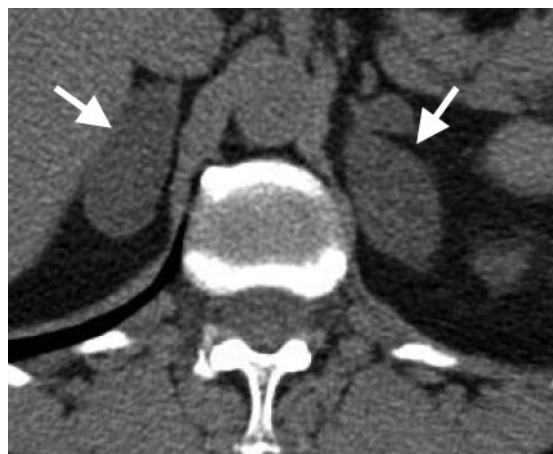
Bilateral adrenal masses on CT (*arrows*).
